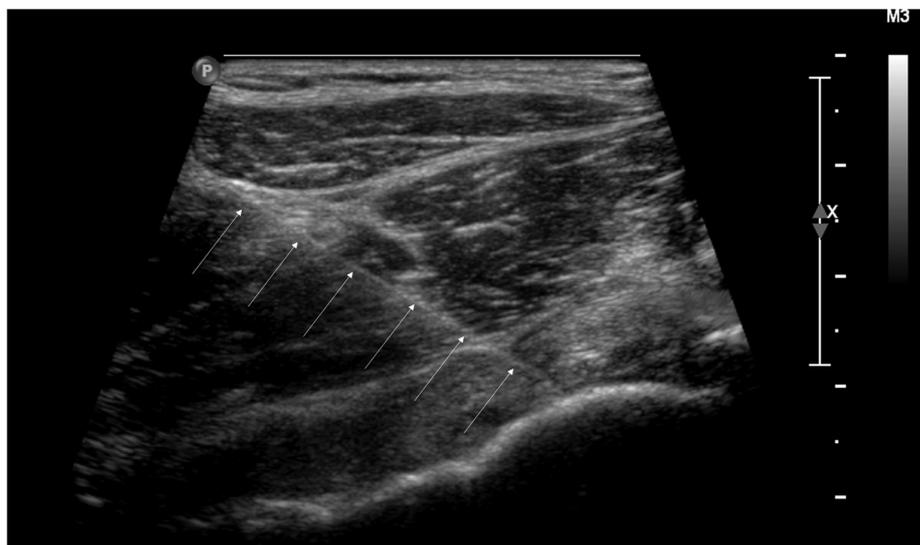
33-year old male soccer player with right hip pain. Longitudinal sonogram showing injection technique for joint injection. 22 gauge “spinal” needle in situ with tip at the femoral head 2 cm inferior to the acetabulum (arrows). Patient received a corticosteroid-local anaesthetic injection via the 22-gauge needle.
